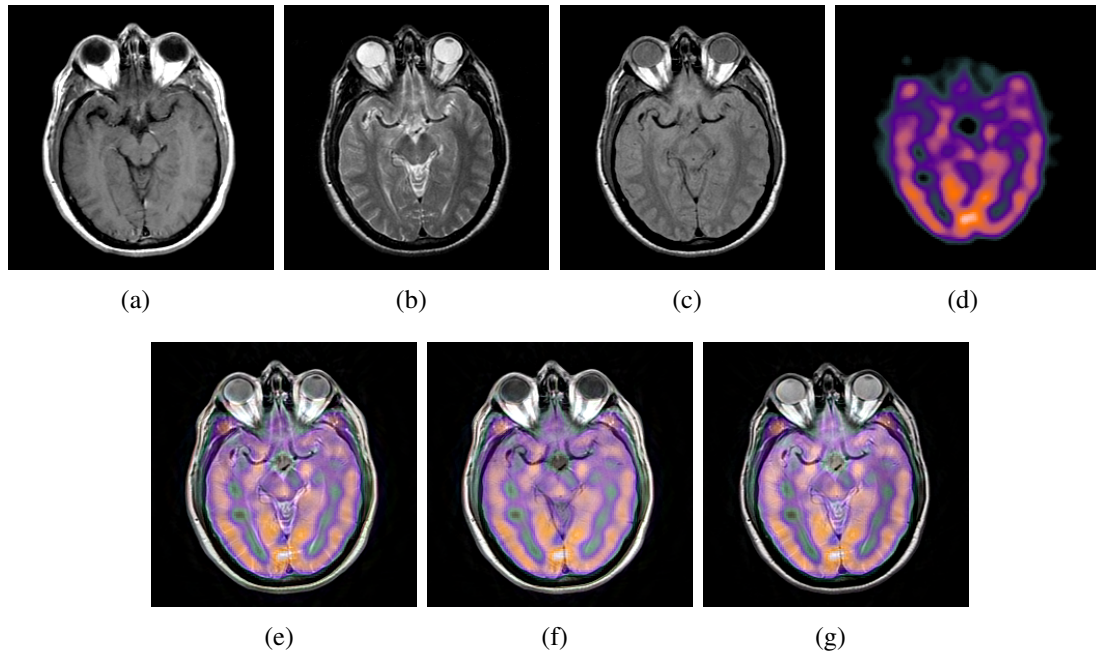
Multimodal fusion of three 2-D real neuroimages (MR-SPECT combinations) of a Lyme encephalopathy patient from the Whole Brain Atlas database. (a) MR-T1 image. (b) MR-T2 image. (c) MR-PD image. (d) SPECT image. (e) Fused image of (a), (b), and (d). (f) Fused image of (a), (c), and (d). Fused image of (b), (c) and (d). NOTE: Figs. 3.20 (a), (b), and (c) are, respectively, the same as Figs. 3.16 (a), (b), and (c), and are repeated here for convenience.
